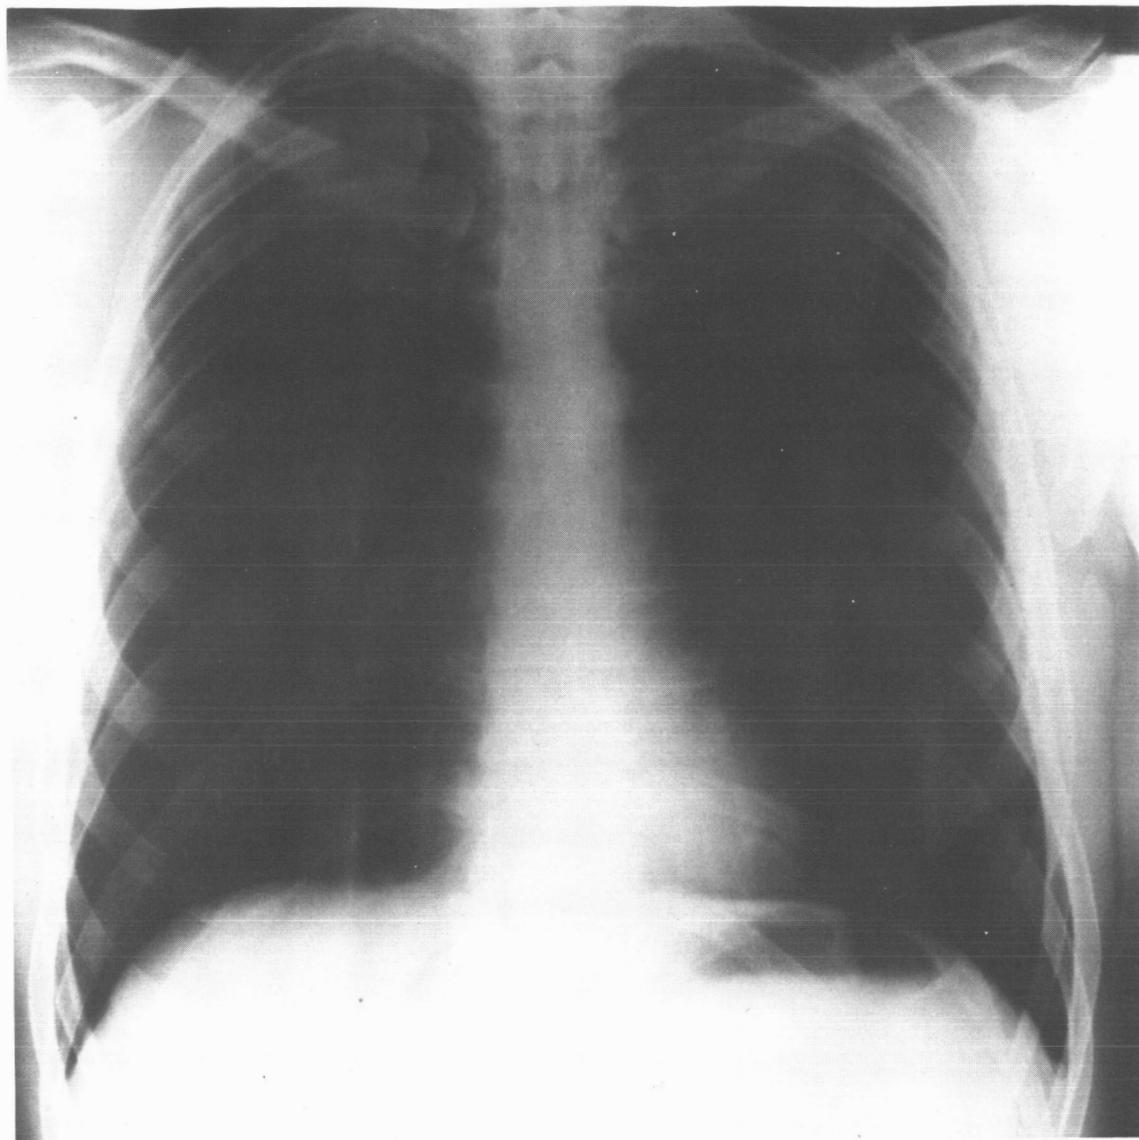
Chest Roentgenogram Showing No Pulmonary Involvement
